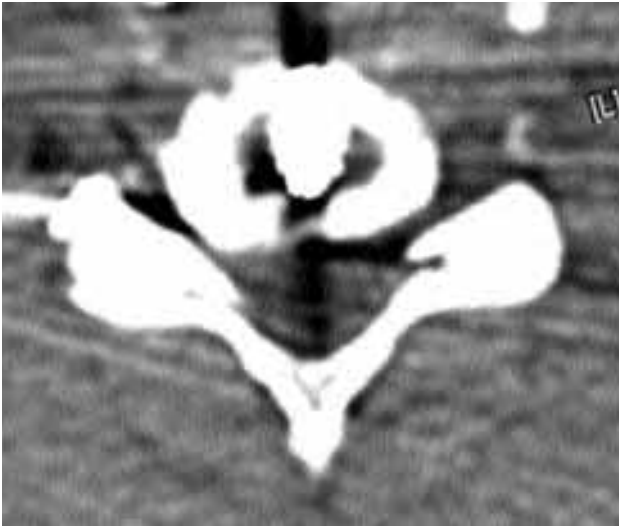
A postoperative CT scan showing the proper positioning of the implant.
